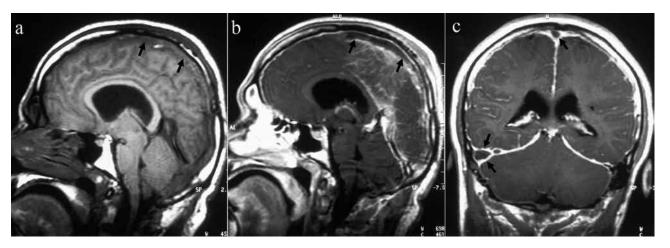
Sagittal T1-weighted (a), contrast-enhanced sagittal (b) and coronal (c) T1-weighted magnetic resonance images show filling defect in the superior sagittal sinus and empty delta sign (black arrows) in the superior sagittal and right transverse sinuses consistent with dural venous sinus thrombosis.
